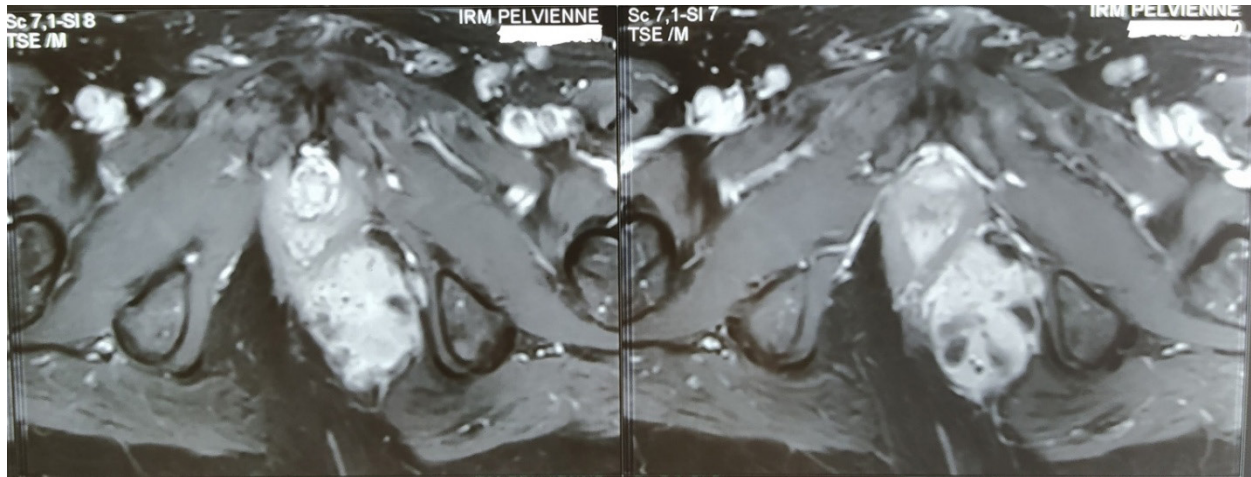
Pelvis MRI axial showing a mass of the left ischioanal fossa, which was measured at about 54x44x72mm.
